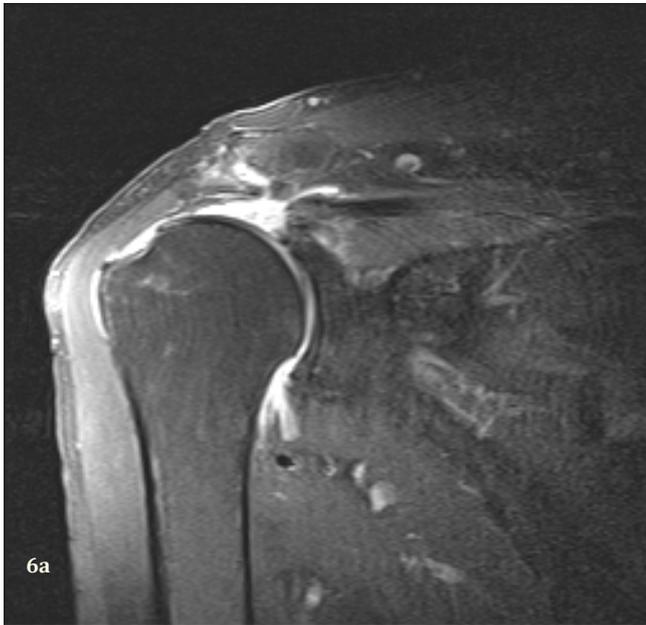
MRI of tear pre-op (6a) and one year post op (6b) in the same patient.
